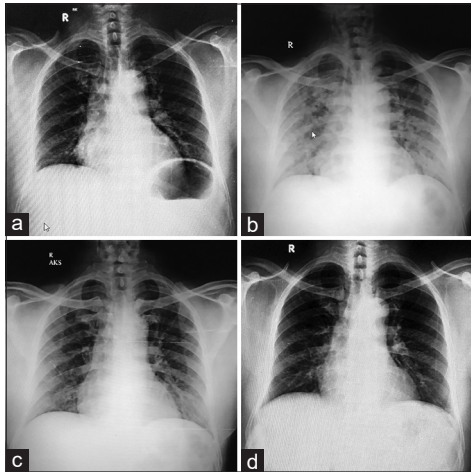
(a) Chest X-ray of Leptospirosis patient - day 1. (b) Chest X-ray of Leptospirosis patient - day 3. (c) Chest X-ray of Leptospirosis patient - day 5. (d) Chest X-ray of Leptospirosis patient - day 8
